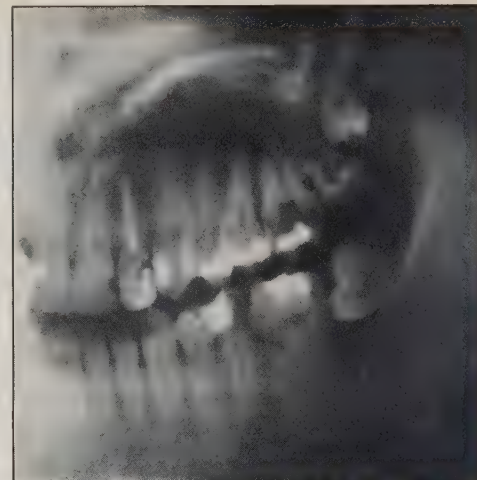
Panoramic radiograph of Case 2 (patient's left side). The lower left first molar is a disto-angular total bony impaction.
